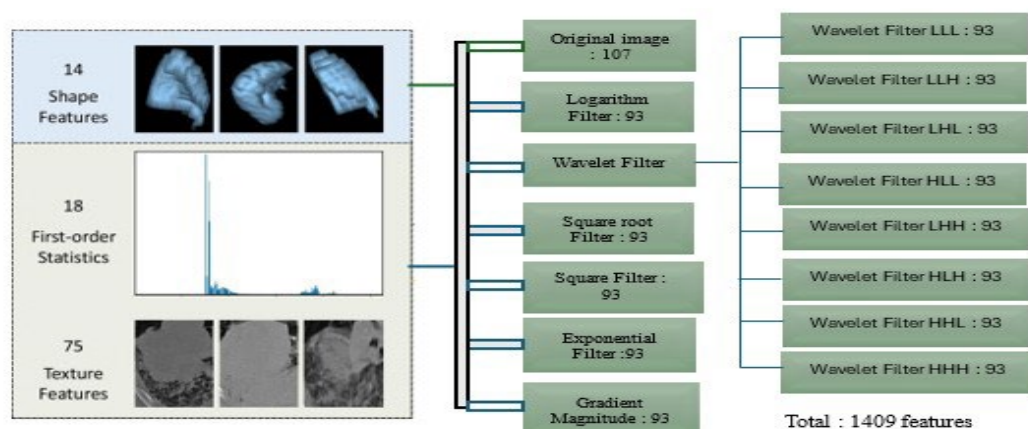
Radiomic features extracted from original and filtered CT images
